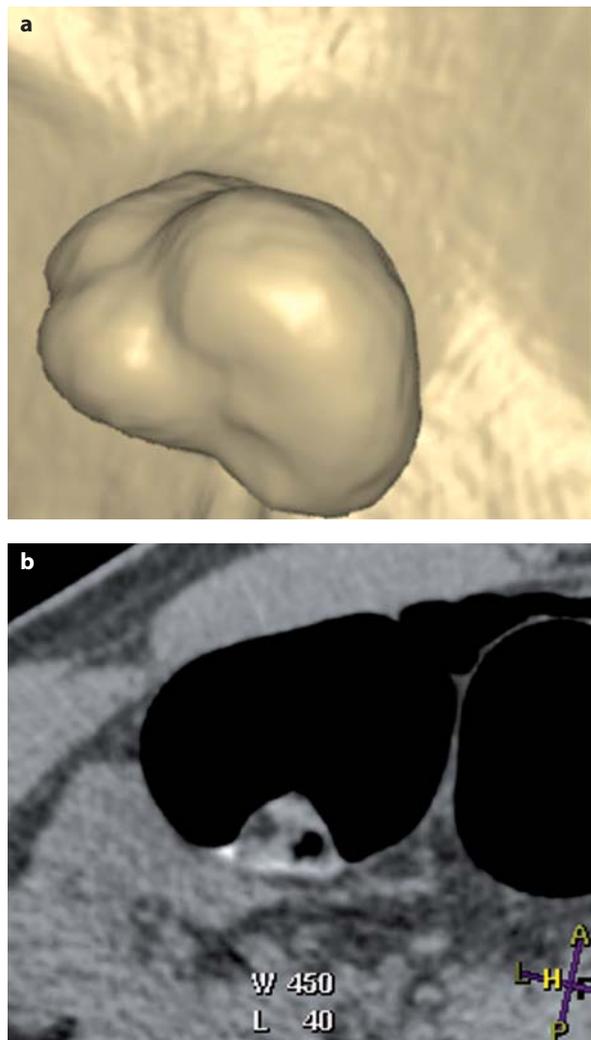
a, b. At CT colonography with fluid tagging, a polypoid lesion is visible in 3D. The lesion is heterogeneous at 2D evaluation and concerns untagged fecal residue
